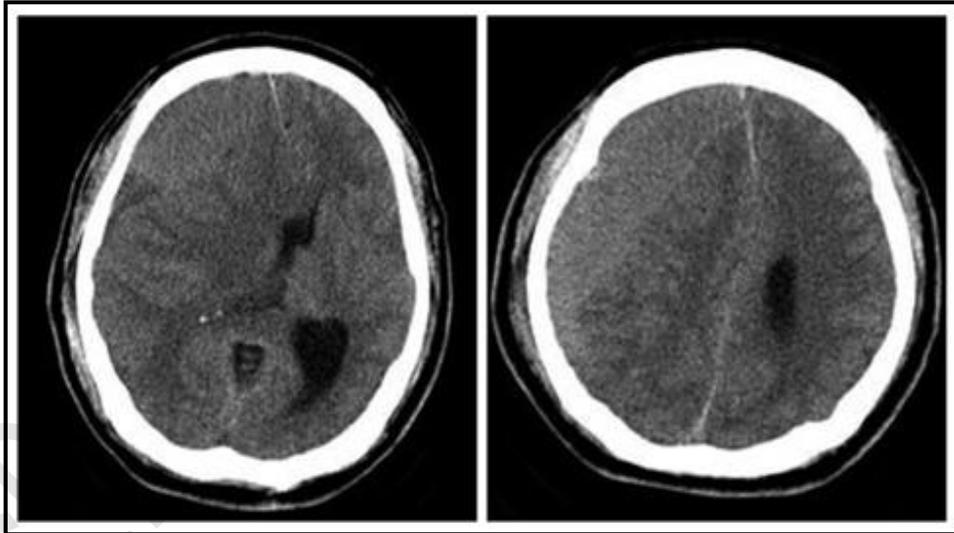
Pre-operative CT scan reveals isodense right chronic subdural hematoma with midline shifting.
